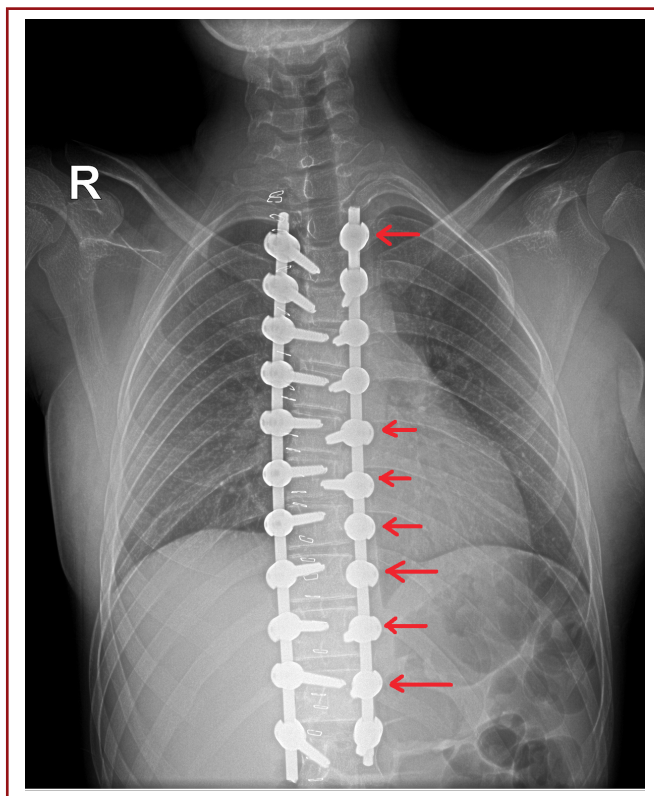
Image of screw malposition in plain posterior radiography.
